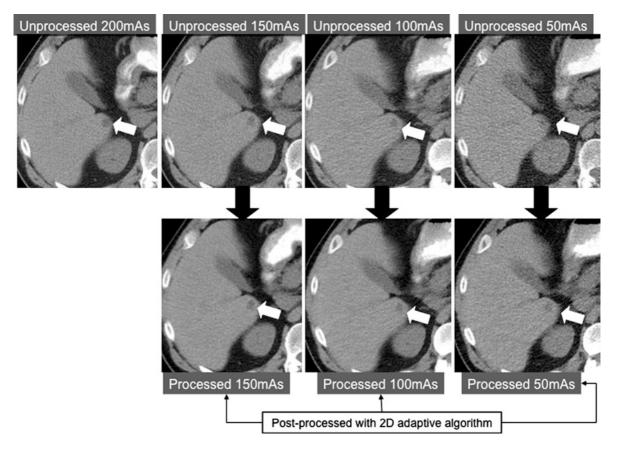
Abdominal CT images acquired at 200, 150, 100 and 50 mAs in the same patient with a limited scan length of 10 cm shows a low attenuation liver lesion. Post processed images
